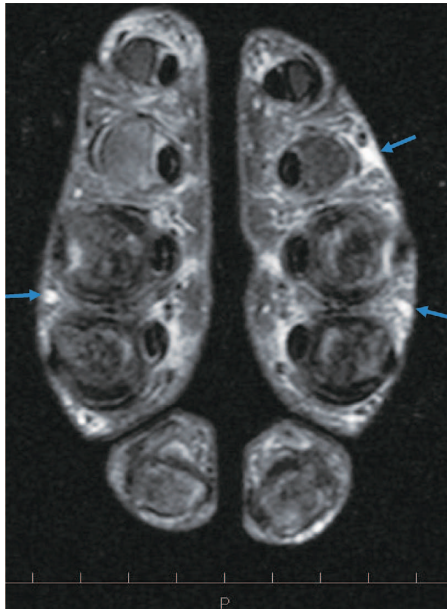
Fat suppressed MRI of the hands. Axial T2 weighted scan through the midpoint of the palm shows inflammatory changes outside the synovial compartments with extra capsular soft tissue edema.
